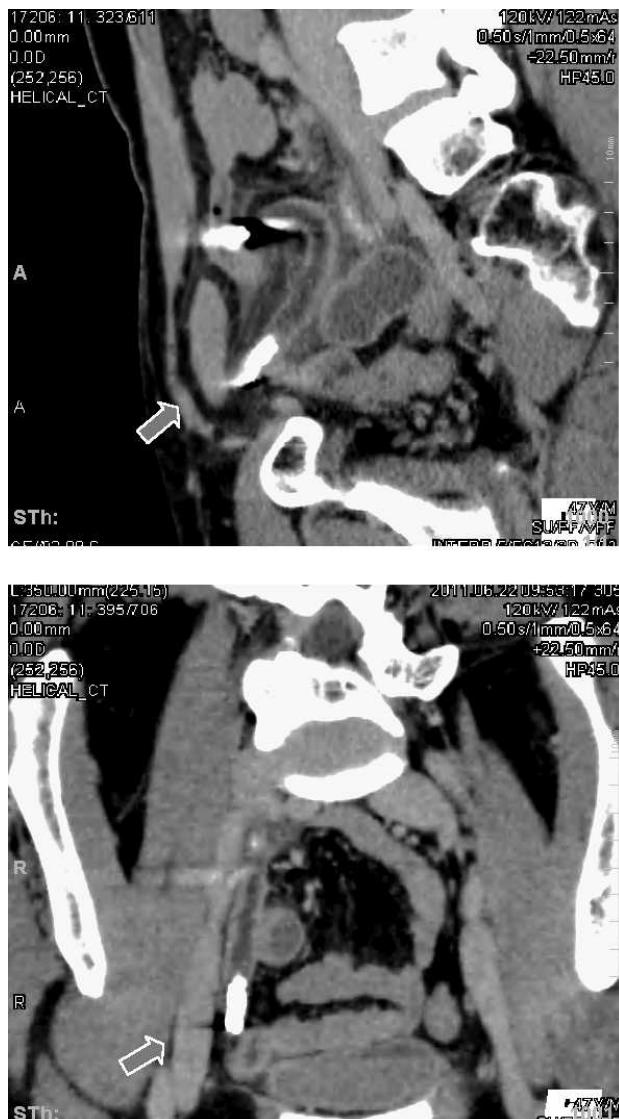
Barium impaction in the appendix and dilatation of its lumen. Multiplanar reconstruction of computed tomography scans.
